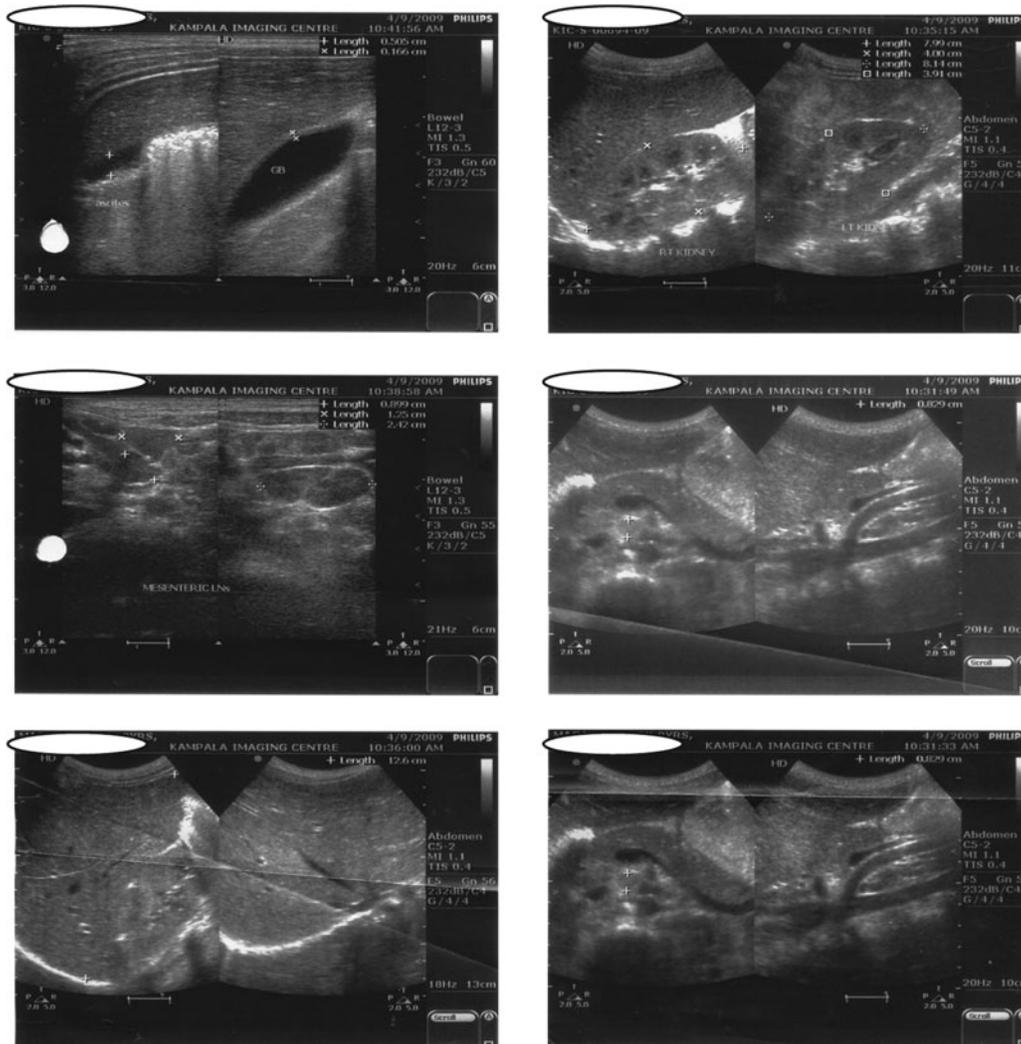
Abdominal ultrasound showing multiple lymphadenopathy along the celiac trunk.
